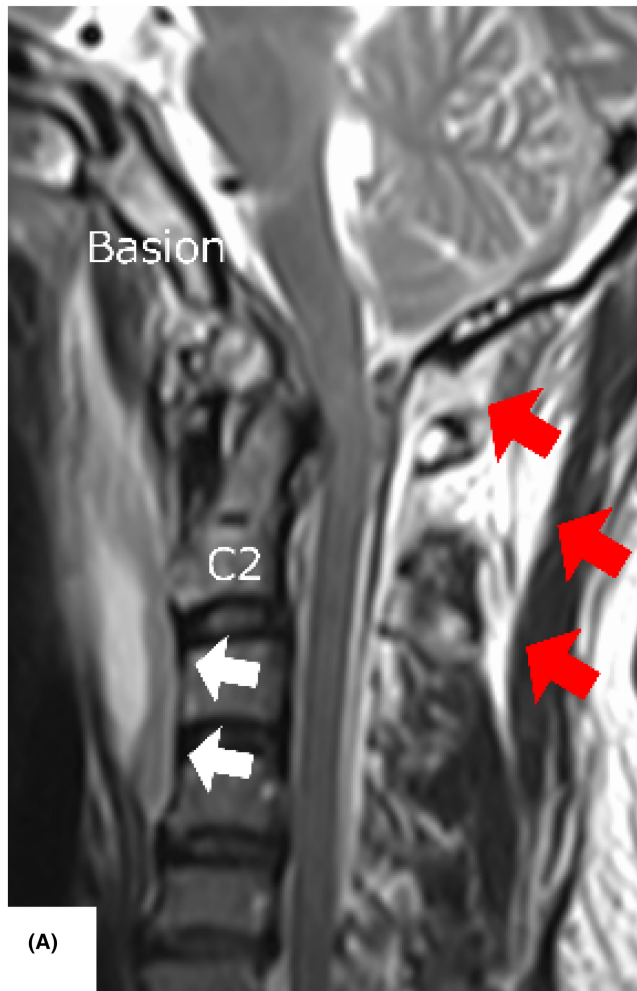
Preoperative cervical spine MRI (sagittal). (A) MRI demonstrates an abnormally high signal intensity in the atlanto-occipital joints, nuchal ligament (red arrow), and retropharyngeal space (white arrow).
